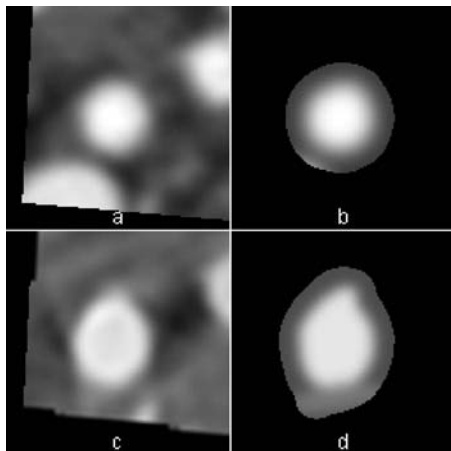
Cross-sections of the common carotid of patient 2, image 16 of the distal reference segment (Fig. 10, at 32.5 mm) (a) shows the CTA image and (c) the 3DRA image. (b) and (d) show the fitted model images, using four Fourier terms. Note the severe streak artifacts in the 3DRA image (c), with background values varying between -600 and 600 , with the intensity of the artery in the order of 1800 (all arbitrary units) and edge enhancement of the artery. These artifacts, probably in combination with some mismatch, cause deviations in the shape of the artery [see (c) in comparison with (a)] and a poor fit (d). As a consequence, the estimated equivalent diameter in (d) is much larger than that in (b) (see Fig. 10). Each image measures $12.8 \times 12.8 \text{ mm}^2$. The window center is 170 HU and the window width is 600 HU for images (a) and (b); the window width and level in the images (c) and (d) were chosen to obtain approximately the same gray values for the artery and background.
